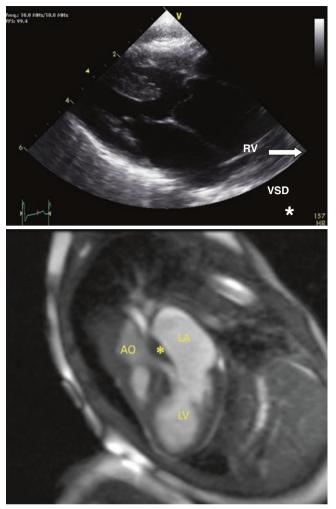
Fallot-type DORV. The ventricular septal defect is subaortic. (a) Echocardiographic parasternal long-axis view of the left ventricular outflow tract. Notice that the aorta is not fully arising from the right ventricle and that there is a sub-pulmonary obstruction (full arrow). There is a mitro-aortic discontinuity (*). (b) MRI 3-chamber view showing similar findings. The * clearly shows muscle mass that separates the aortic and mitral annulus, reflecting the presence of a subaortic conus
